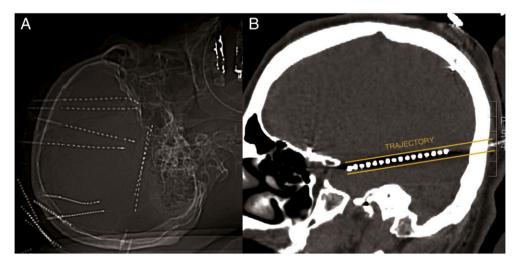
Panel A-Radiograph showing typical SEEG implantation including bilateral transoccipital electrodes; Panel B- Representative SEEG map showing electrode implantation targets and placement.
